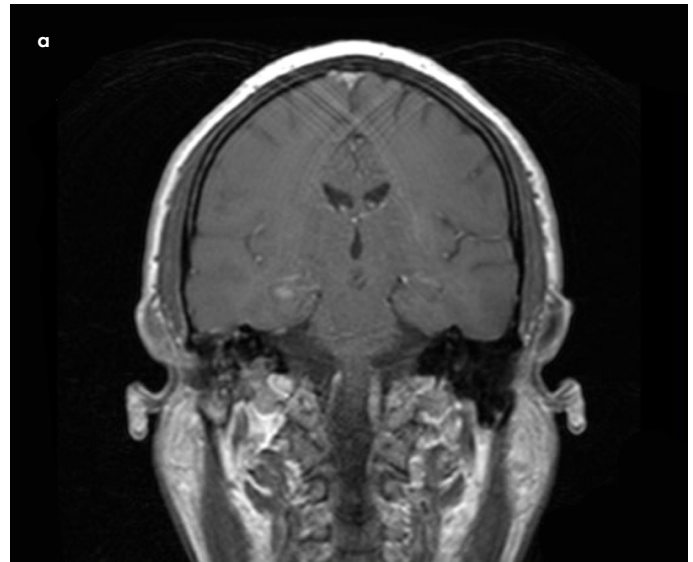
a, b. T1-weighted coronal MRI showing hyperintense lesion and contrast enhancement in the hippocampus. MRI: magnetic resonance imaging.
